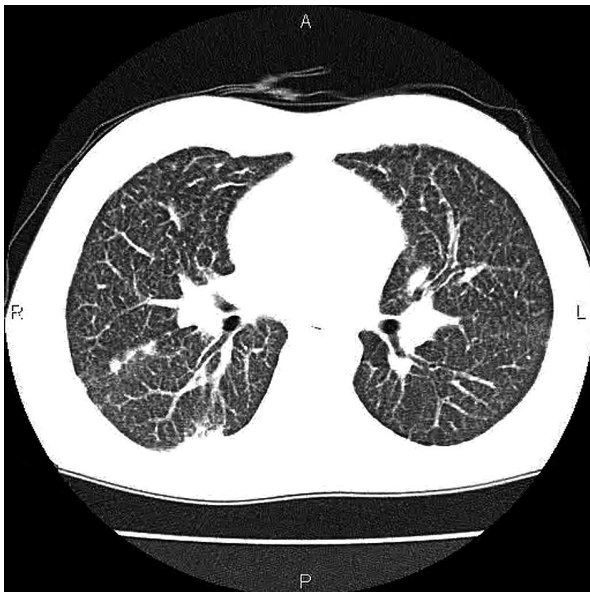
HRCT imaging of the IgG3 deficient patient with chronic interstitial lung disease and surfactant protein C deficiency
